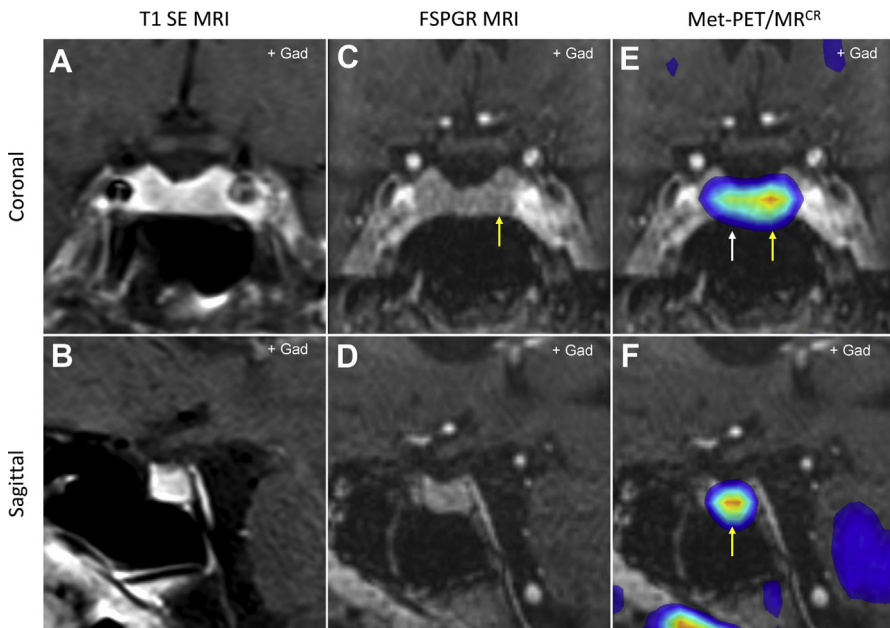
Identification of the site of an occult microadenoma in Cushing disease. (A, B) T1 SE MRI is unable to identify a discrete adenoma. (C, D) Volumetric (FSPGR) MRI is also equivocal, but raises the possibility of a subtle area of hypoattenuation in the left side of the gland (yellow arrow). (E, F) Met-PET/MR^{CR} demonstrates focal increased tracer uptake (yellow arrow) corresponding to the area seen on volumetric MRI (and subsequently confirmed at TSS); normal physiologic tracer uptake is seen in the right side of the gland (white arrow).
